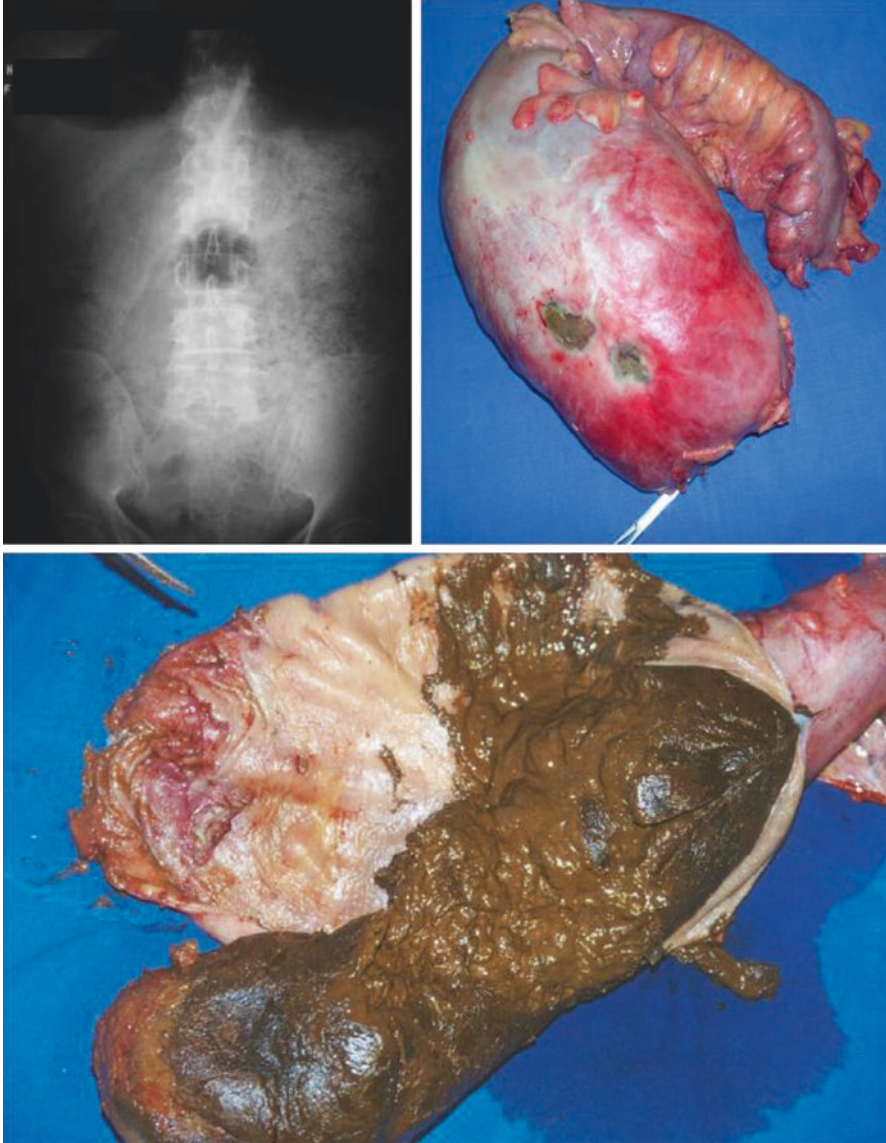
Plain abdominal X-ray showing large fecaloma; colon perforation due to fecaloma; partial colectomy and fecaloma. Picture courtesy of Dr. Ê. Chaves de Oliveira
